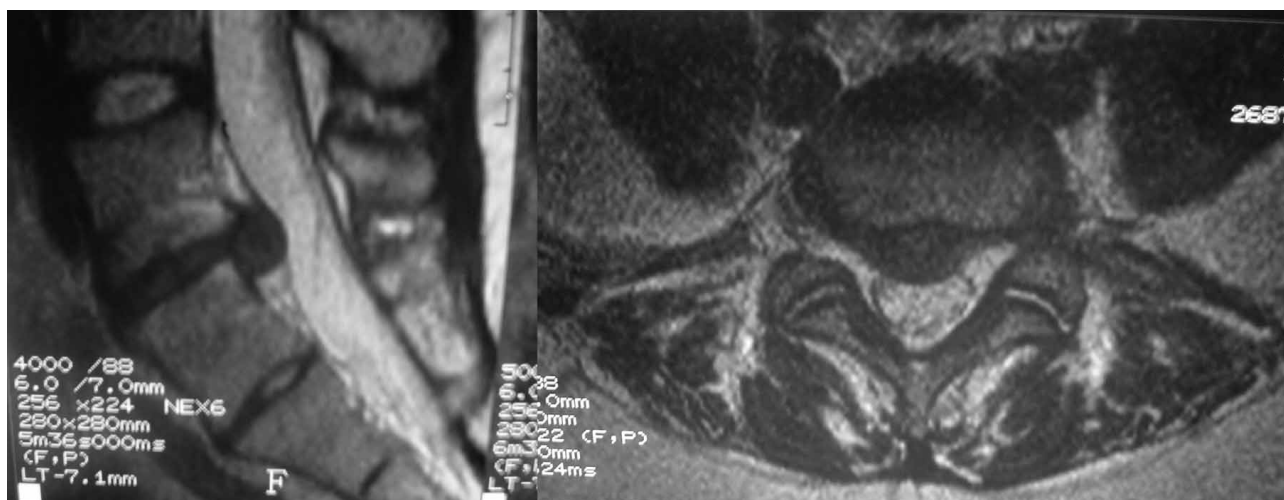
MRI shows disc hernia with intact posterior longitudinal ligament.
